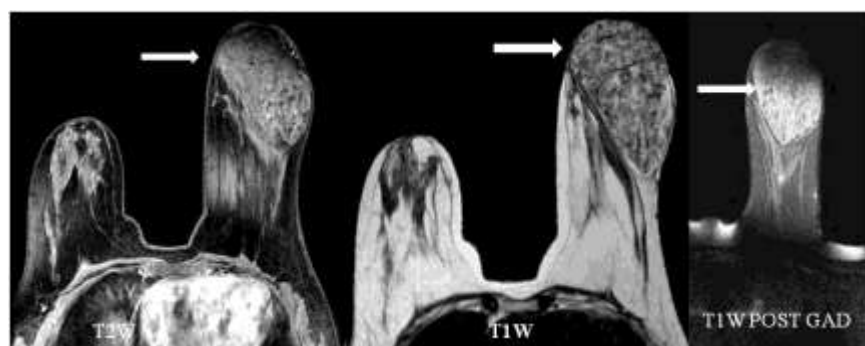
Magnetic resonance imaging: T1W, T2W fat suppressed and post contrast images reveal a well-defined, well marginated mass with fat, glandular and fibrous component with post contrast enhancement. Fat suppressed images confirm the fat component within the mass
